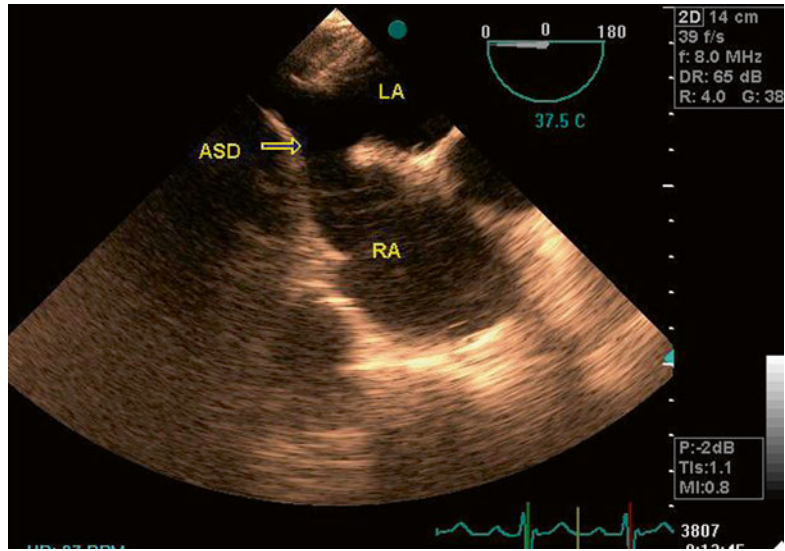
(a, b) Transesophageal echocardiography (TEE) in bicaval view (90°), confirming the sinus venous-type atrial septal defect diagnosis. RA right atrium, LA left atrium, SVC superior vena cava, ASD atrial septal defect
